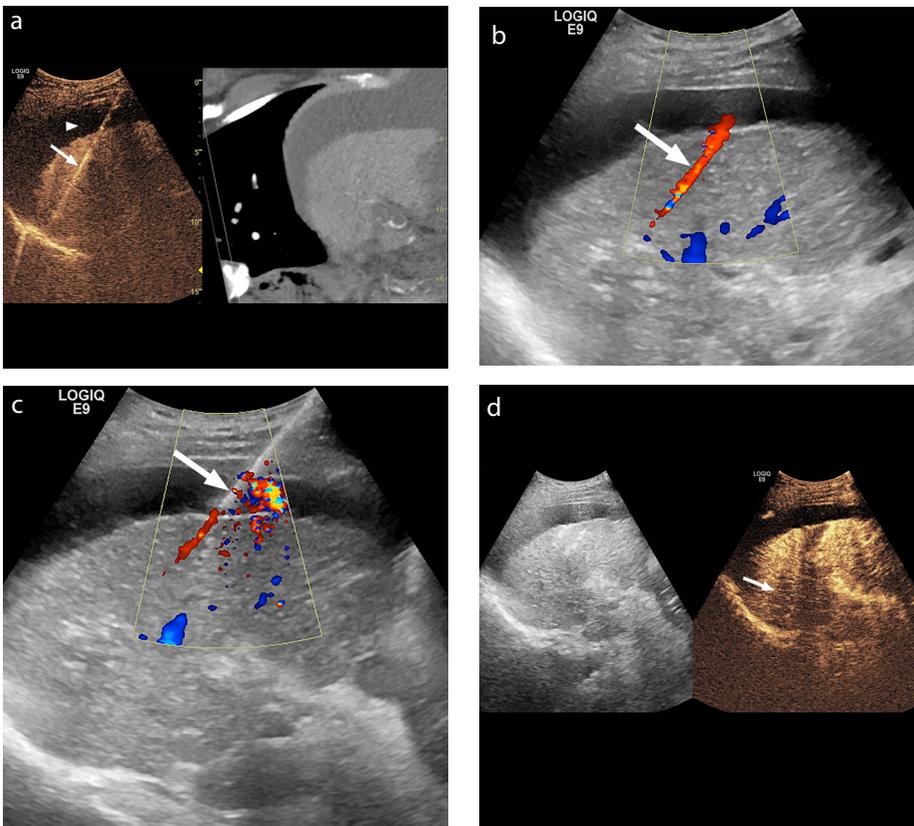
(a-d) Repeat cauterization of the needle tract bleeding after microwave ablation (MWA) of a recurrent segment 7 hepatocellular carcinoma. Fusion contrast-enhanced ultrasound (CEUS) with computed tomography (a) was performed to guide the MWA needle (arrow). Concomitant ascites (arrowhead). After removing the ablation needle, Doppler interrogation of the needle track (b) demonstrates a linear color Doppler flow (arrow) along the needle tract, indicating active bleeding. (c) The ablation needle (arrow) was immediately reintroduced under real-time ultrasound guidance to the needle entry point at the liver's surface, and repeat cauterization was performed. Post-ablation CEUS (d) demonstrates complete ablation of the lesion (arrow) with no evidence of active bleeding from the needle tract.
